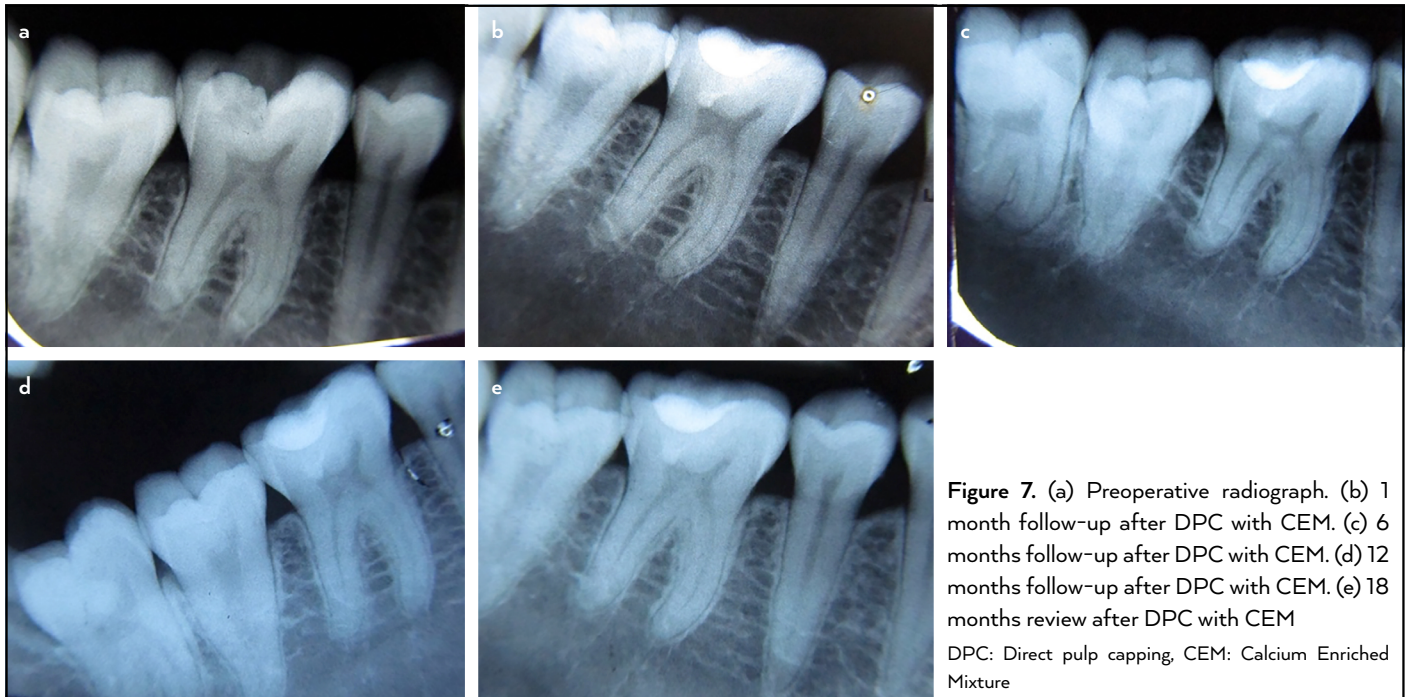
(a) Preoperative radiograph. (b) 1 month follow-up after DPC with CEM. (c) 6 months follow-up after DPC with CEM. (d) 12 months follow-up after DPC with CEM. (e) 18 months review after DPC with CEM
